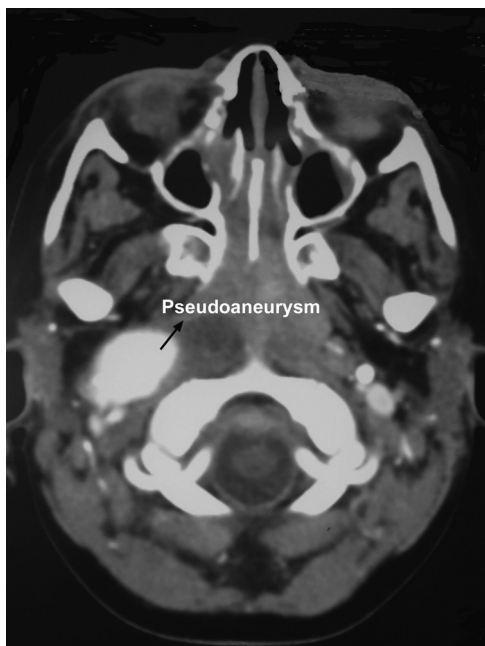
Contrast-enhanced CT scan axial section at the level of the oropharynx demonstrates an ovoid enhancing right parapharyngeal mass. This is situated at the anatomical position of the ICA and was consistent with an ICA pseudoaneurysm.
